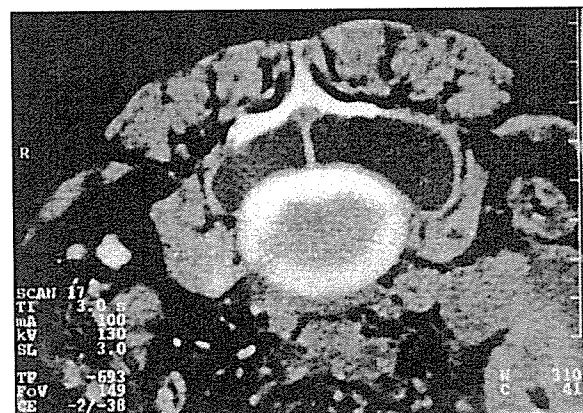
Preoperative axial CT scan showing well-capsulated intracanal huge cyst.
